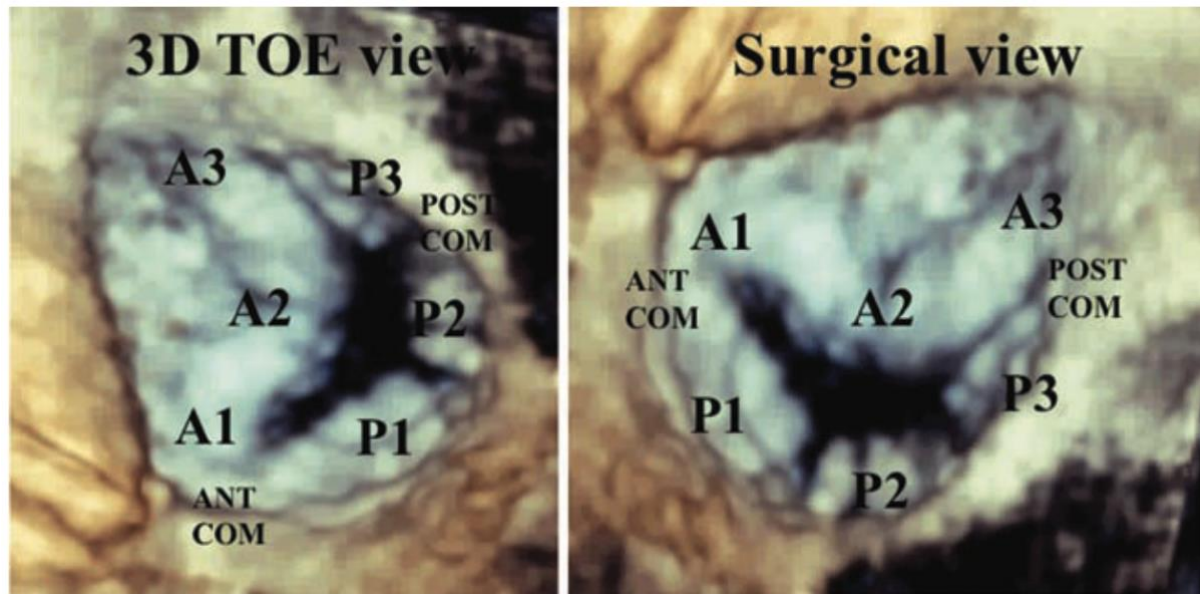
Three-dimensional transesophageal echocardiography (TEE) of the mitral valve. The left image shows standard TEE view. The right image shows the surgical view of the mitral valve. A1-3, scallops of the anterior leaflet. Ant com, anterior commissure. P1-3, scallops of the posterior leaflet. Post com, posterior commissure. (Lancellotti, Tribouilloy et al. 2013)
